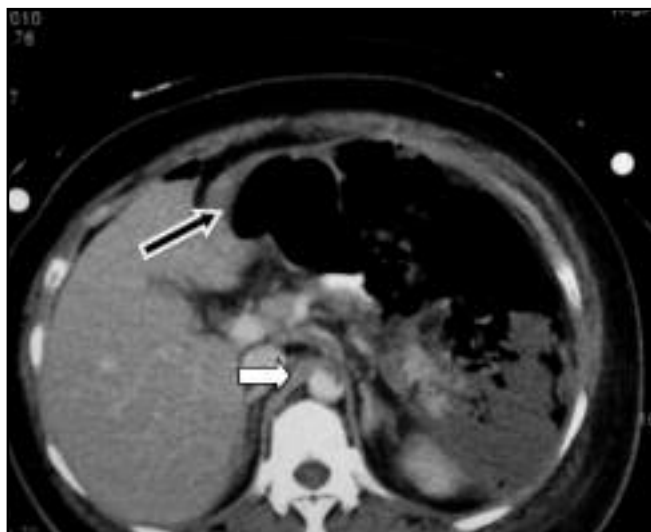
CT Abdomen with contrast(oral &IV) showing celiac artery thrombosis (white arrow) and pneumoperitoneum (black arrow)
